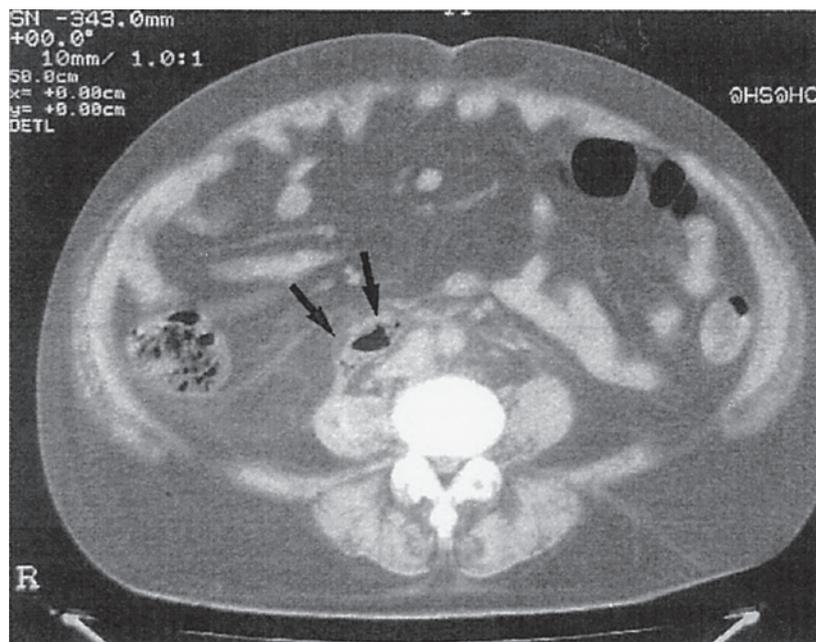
CT scanning showed that abscess with gas formation in front of the L3 vertebral bone(→) (CASE 3)
